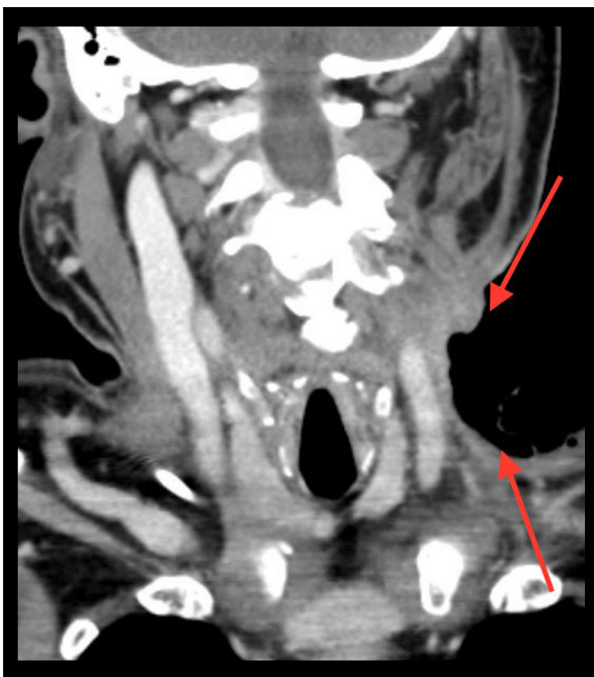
Computed tomography image demonstrating complete remission with chemotherapy. Arrows denoting area previously occupied by tumor.
